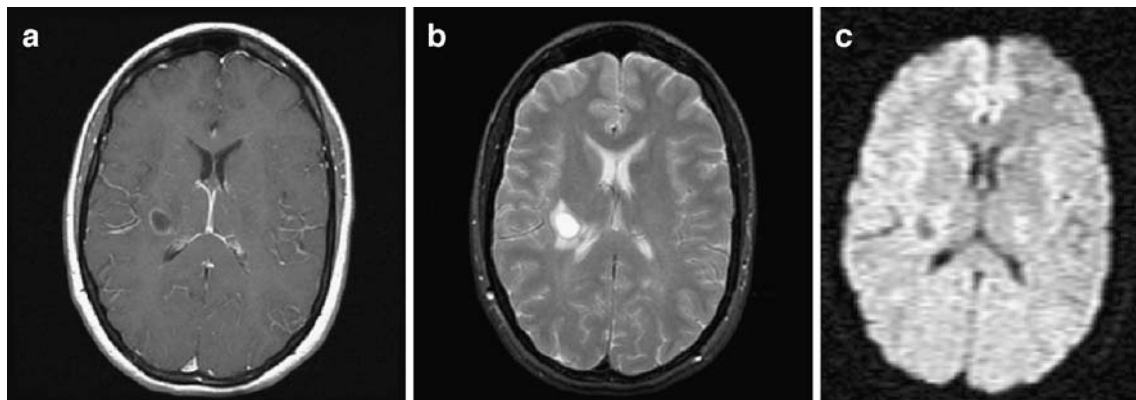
a MS lesion with ring-enhancement on T1-weighted MR imaging with gadolinium. b This lesion has a peripheral hypointense rim and is homogeneous centrally on T2-weighted MR imaging. c DW imaging shows a mixed, although mostly dark, signal
